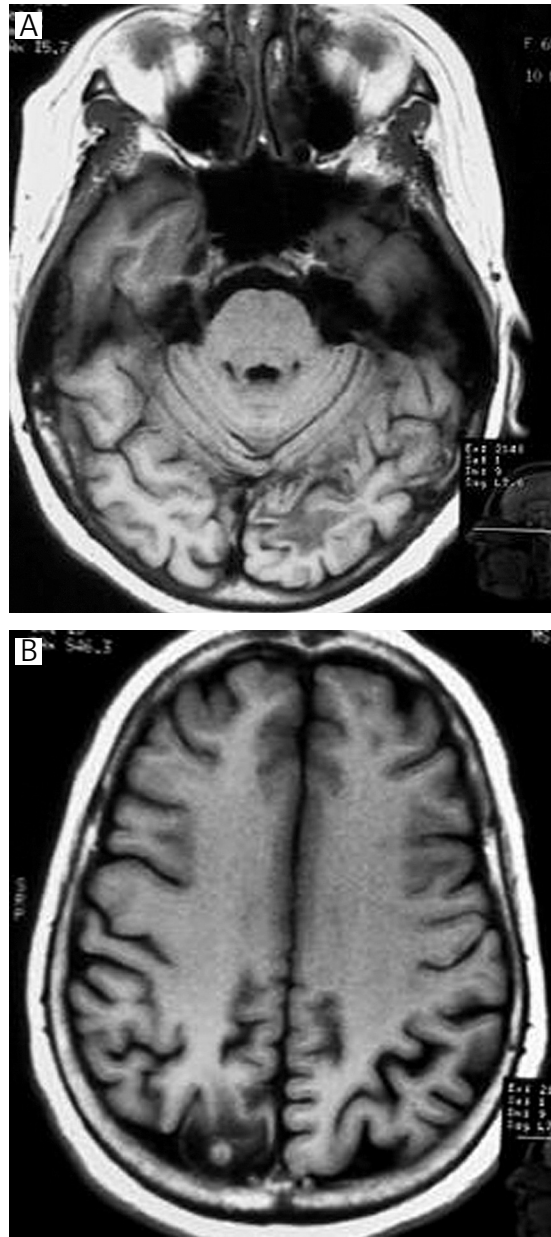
Brain MRI one year later showing near complete resolution of the ring enhancing lesions with disappearance of the surrounding vasogenic edema
